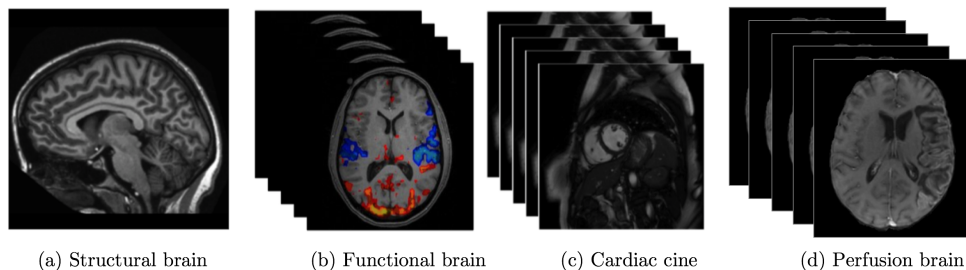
Examples of different MR image modalities. Structural MR for brain (a) is a static scan, functional brain MR (b), cardiac cine (c) and perfusion brain (d) are dynamic modalities. (Image adapted from [12])
